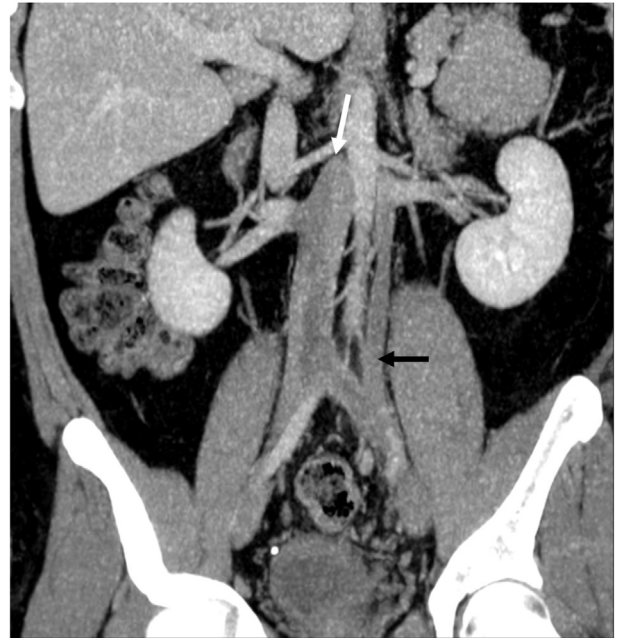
Computed tomography angiography, coronal reconstruction shows discontinuity of the inferior vena cava at suprarenal level (white arrow), duplicated inferior vena cava draining in to the left renal vein (black arrow).
